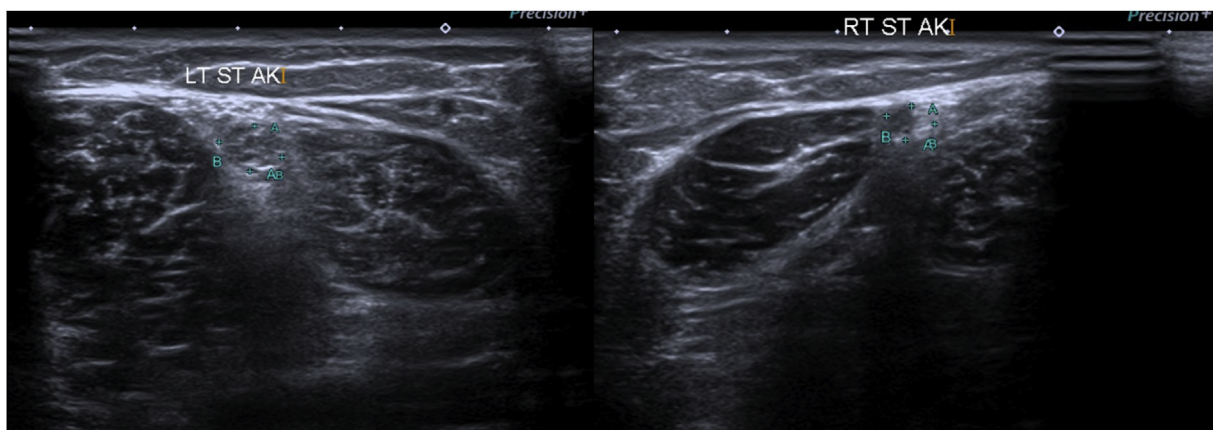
Shows ultrasonographic image of both knees (left operated). Regenerated tendon can be seen in zone 1 (4 cm above the lateral joint line) of the operated knee.
